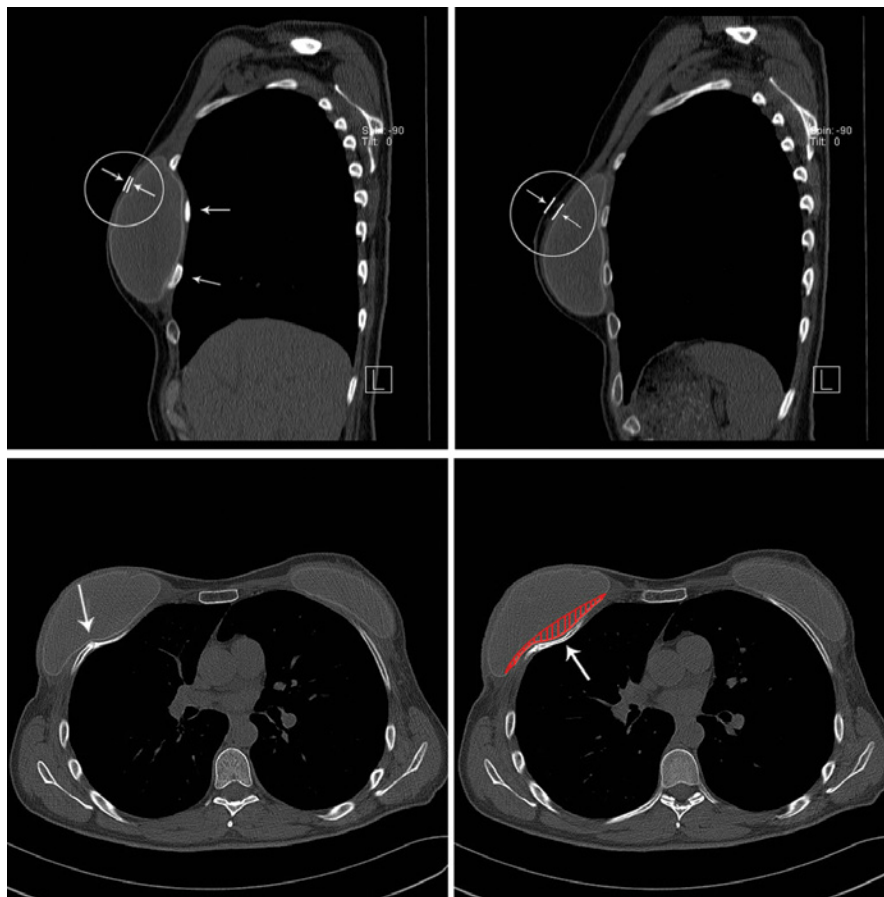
CT scan of the thorax after the positioning of permanent anatomically shaped silicone implants (sagittal section – upper, transverse section–lower). The left upper picture shows the position of the right implant, whereas the right upper picture shows the position of the left implant. Notice that the right implant is protruding posteriorly and that the 4th and 5th ribs are also displaced posteriorly, away from their normal position (smaller arrows). Arrows in both circles also indicate different thickness of the overlying soft tissue envelope. Lower pictures indicate fracture of the 4th rib on the right side (left bigger arrow) and a posterior protrusion (right bigger arrow) of the implant in two adjacent transverse sections. The left 4th rib shows no signs of fracture or protrusion. The area covered with red stripes indicates the overall volume of implant depression. Implant dimensions: Left–CPG™ 322 (295 cm³); width 11.5 cm; height 10.8 cm; projection 4.9 cm. Right–CPG™ 323 (390 cm³); width 12.0 cm; height 11.3 cm, projection 6.0 cm
